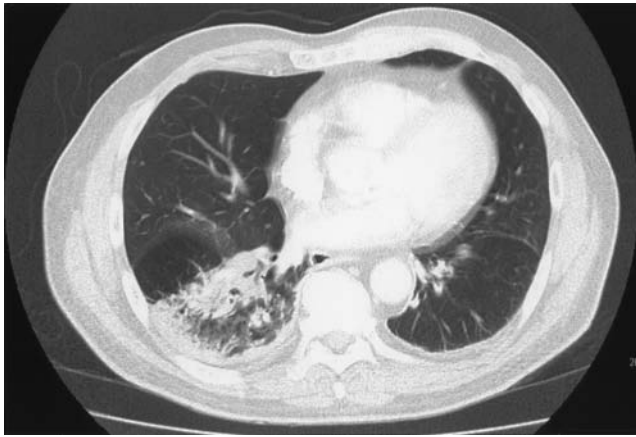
High resolution CT scan of chest showing consolidation of right lower lobe with impingement on pleura.
